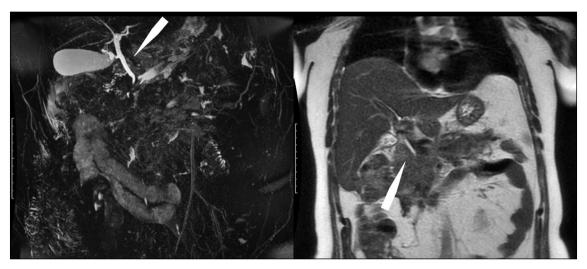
Magnetic resonance imaging cholangiography (left) and T2-WI (coronal plane, right). The distal part of the common bile duct is "hidden" in the infiltrate; the proximal part of the common bile duct and the intrahepatic bile ducts are not dilated (arrows)
